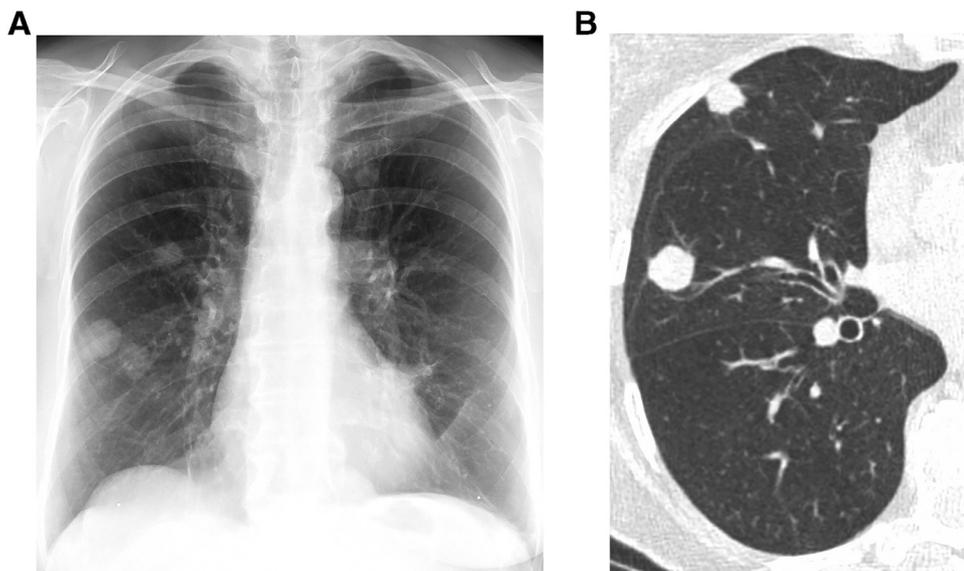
A 47-year-old female with slowly growing rheumatoid necrobiotic nodules. PA radiograph (A) and HRCT image (B) show multiple large well-defined nodules. PA, posteroanterior.
